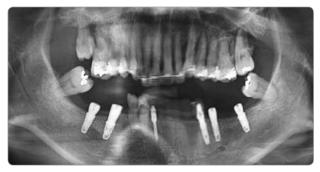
Mandibular post-op radiography
